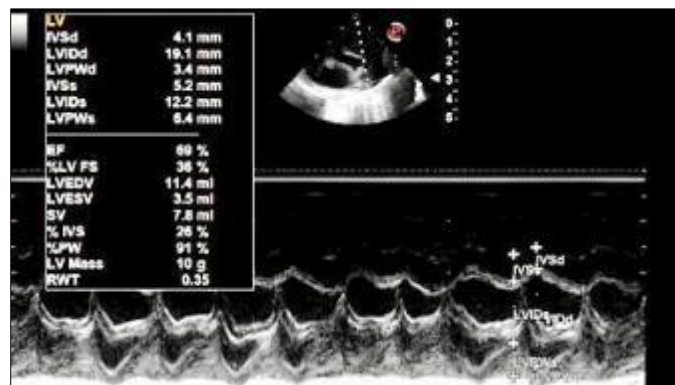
M-mode echocardiography. There was left ventricular dilation and normal LV systolic functions
